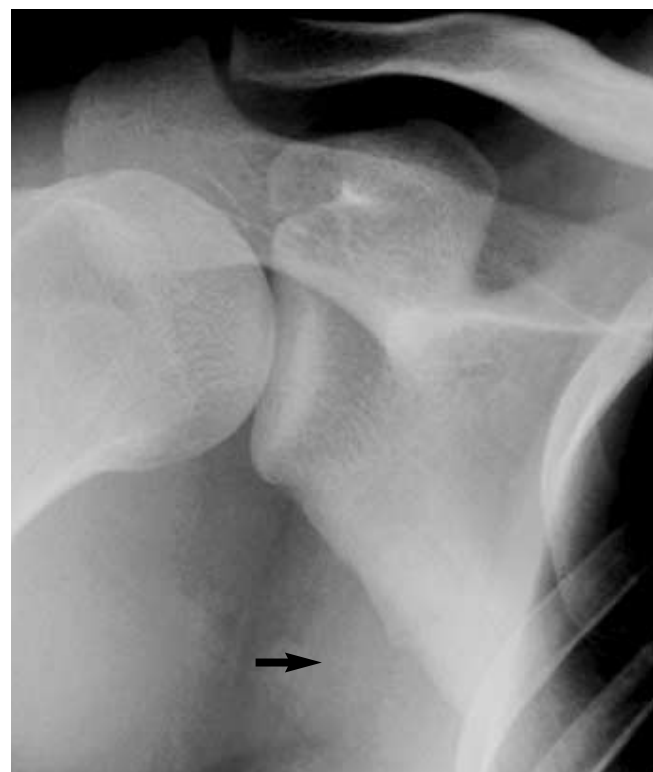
Plain film showing a fracture of the lateral scapular border.
